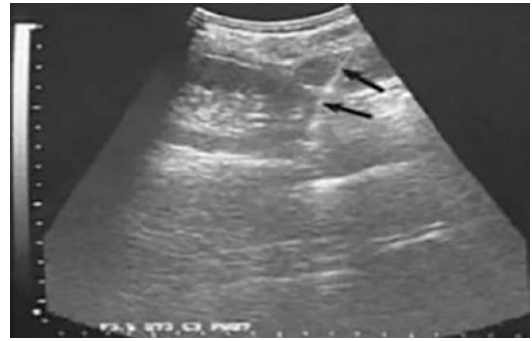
Renal biopsy imaging. An ultrasound scan shows the needle entering the lower pole of the left kidney
